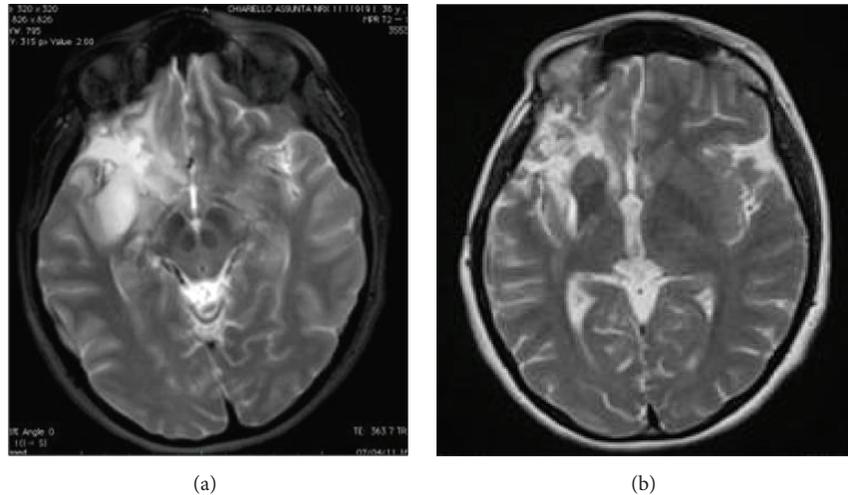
(a) Showing a TR 62 months after the first surgery. The patient did not receive any adjuvant therapy since the first surgery. The volumetric data at first surgery are shown in Figure 2. At second surgery the preoperative tumor volume computed on T2-weighted MRI was  $37 \text{ cm}^3$ . Volumetric analysis of postoperative tumor residue computed on T2-weighted MRI showed a tumor residual volume of  $4 \text{ cm}^3$  (axial slices), which has grown mainly in the previous cavity (b). The extent of the tumor volume resection, computed on a T2-weighted MRI sequences, was 91%.
